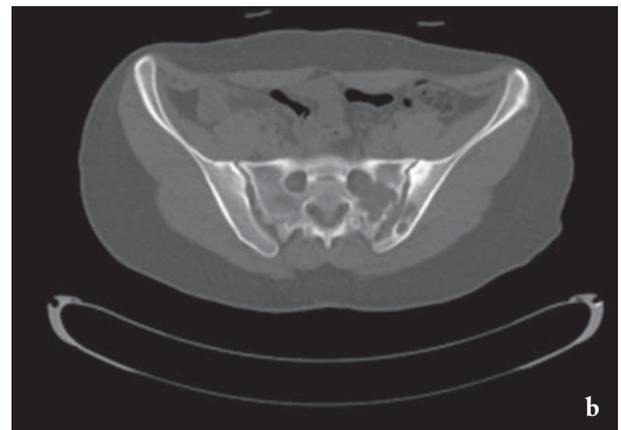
a. A plain pelvic radiograph showing an expansive destructive lesion on the left lateral sacrum extending through the right SIJ and iliac bone. b. Computerized tomography (CT) scans showing multiloculated cysts located in the left hemisacrum expanding the S1–2 neural foramen and extending to the iliac bone and SIJ. c. T1-weighted MRI revealing a hypointense cystic lesion in the S1 and S2 sacral ala, extending to the right SIJ and invading through the sacral canal with displacement of the S1 and S2 nerve roots.
